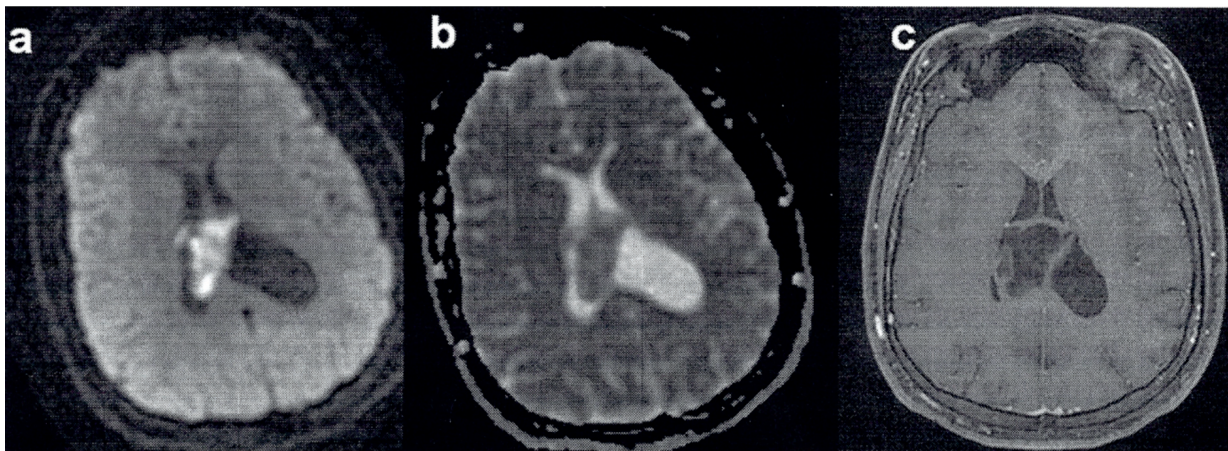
Imaging sequences. a, DWI Sequences: present markedly restricted diffusion with hyperintensity. b, Relative ADC Maps: exhibit the lesion as isointense to parenchyma. c, T1 3D Fat Sat PGR: specific details can be described here depending on the context of the image.
